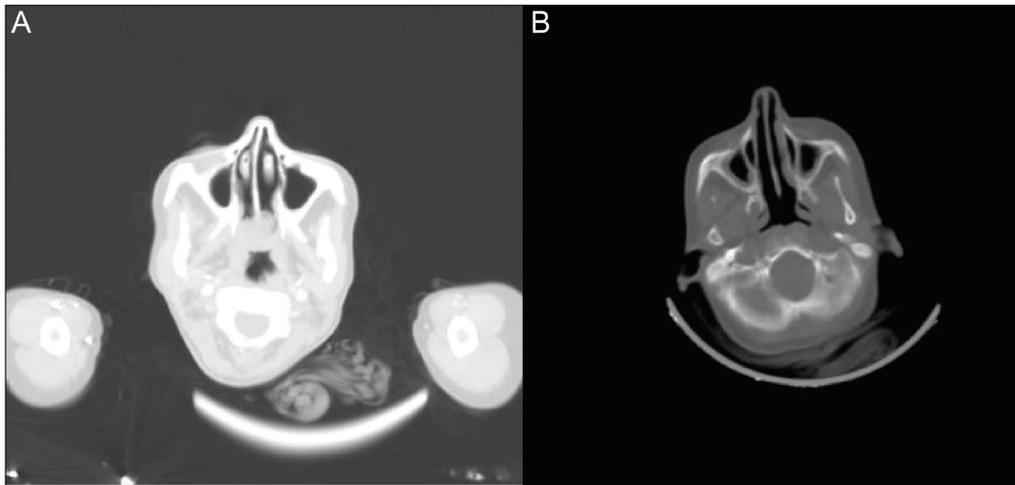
Axial sections of computed tomography scan showing the lesion obstructing the nasopharynx before (A) and after treatment (B)
